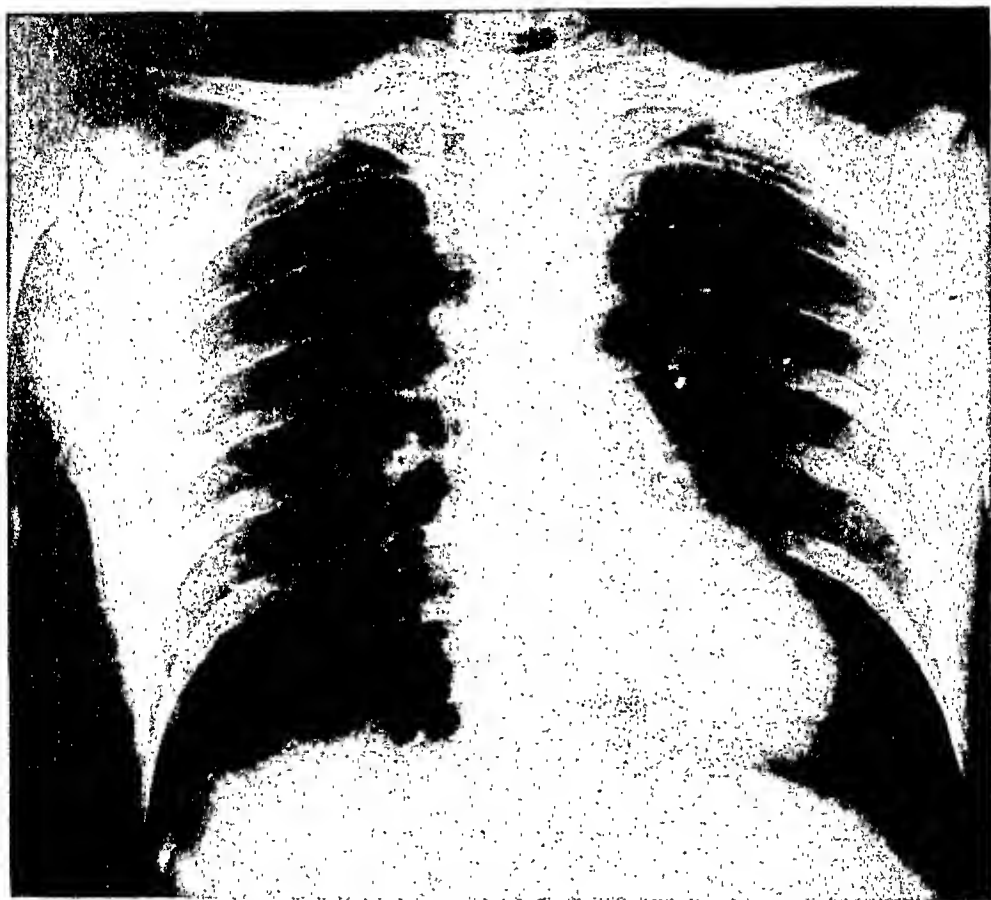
An ordinary x-ray film of a patient with a coarctation of the aorta.
